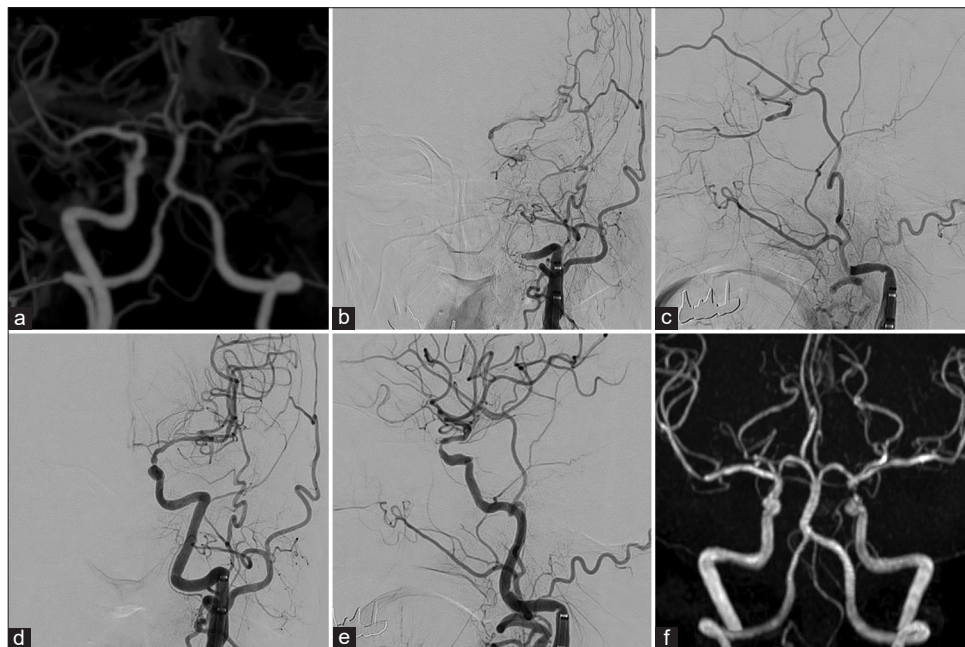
Perioperative images of thrombectomy performed 1-year ago. (a) Preoperative CTA showing left ICA occlusion. (b and c) Preoperative angiography showing occlusion of the left ICA and collateral vessels in the C2 portion of the ICA from the external carotid artery and ophthalmic artery to the distal ICA (b: frontal view, c: lateral view). (d and e) Postoperative angiography showing TICI 2b recanalization and WASID 68% stenosis in the C3 portion of the left ICA (d: frontal view, e: lateral view). (f) Magnetic resonance angiography the day after thrombectomy showing the patency of the left ICA. ICA: Internal carotid artery, TICI: Thrombolysis in cerebral infarction, WASID: Warfarin-aspirin symptomatic intracranial disease.
